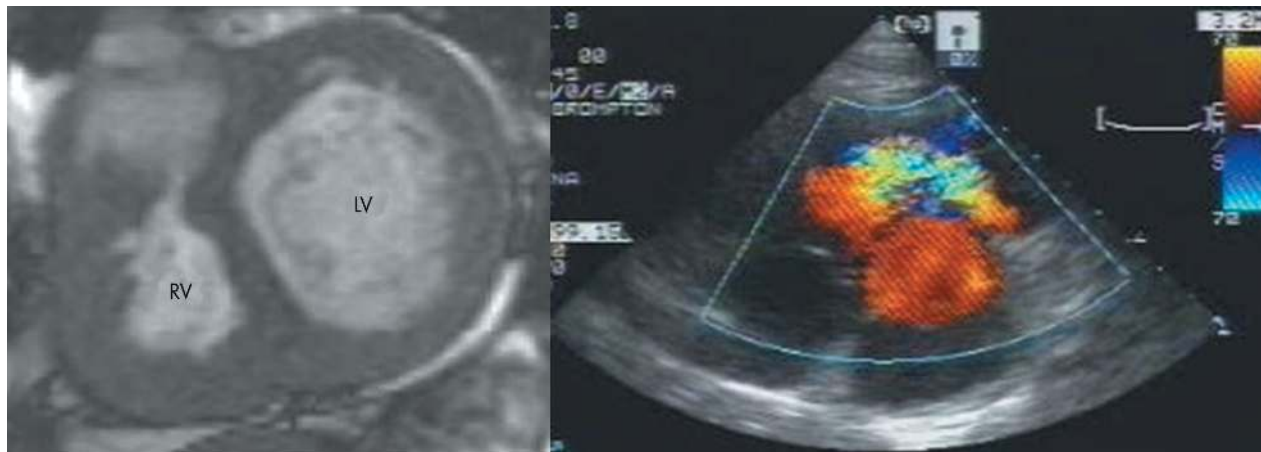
Left panel: Gradient echo (white blood) CMR sequence, oblique sagittal plane (short axis of the ventricles), end systole. The RV is divided into two chambers by a thick ring of ventricular myocardium. This anomaly is called "double chambered RV". Right panel: Echocardiographic colour flow mapping (short axis left parasternal view) of the same patient shown on the left. There is blood turbulence (aliasing) within the RV at the level of the hypertrophic muscle bands. LV, left ventricle; RV, right ventricle.
